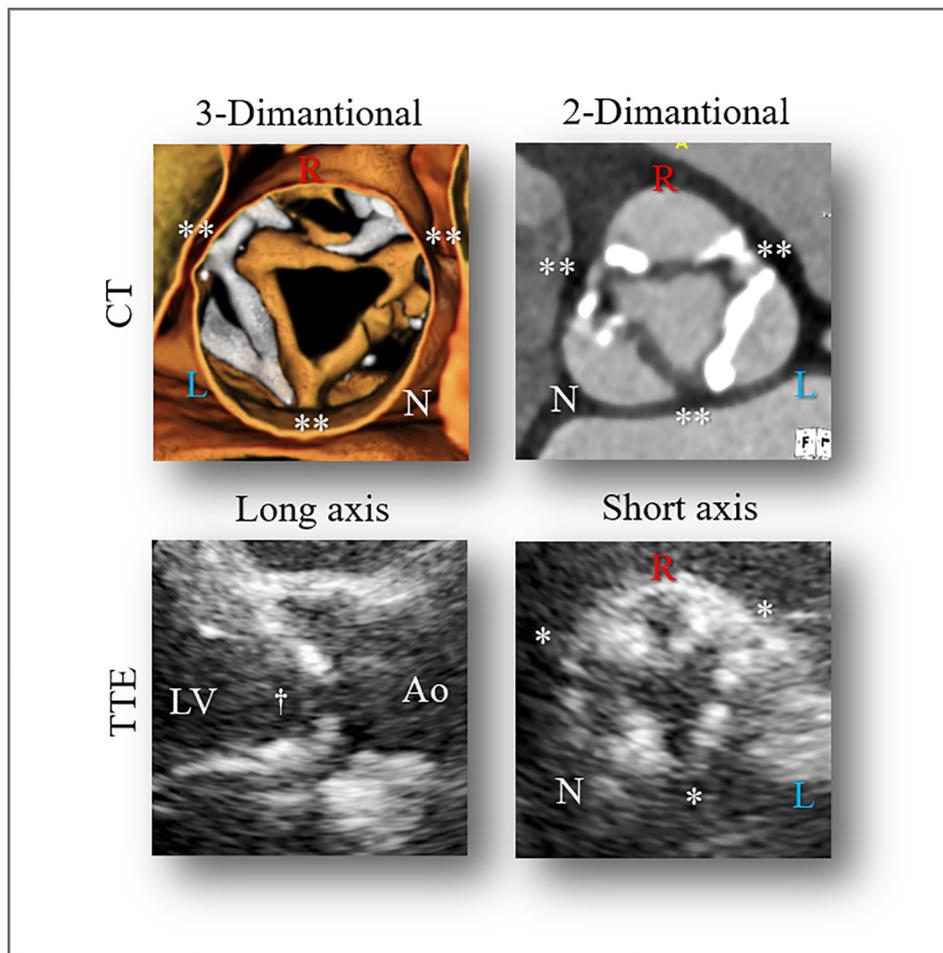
Representative images of rheumatic heart disease case (case 10). Irregular valve thickening and commissural fusions can be seen by computed tomography with higher resolution than those with echocardiography (). The three-dimensional computed tomography image is a mirror image of the two-dimensional computed tomography image. Ao: aorta; CT: computed tomography; L: left coronary cusp; LV: left ventricle; N: noncoronary cusp; R: right coronary cusp; TTE: transthoracic echocardiography.
